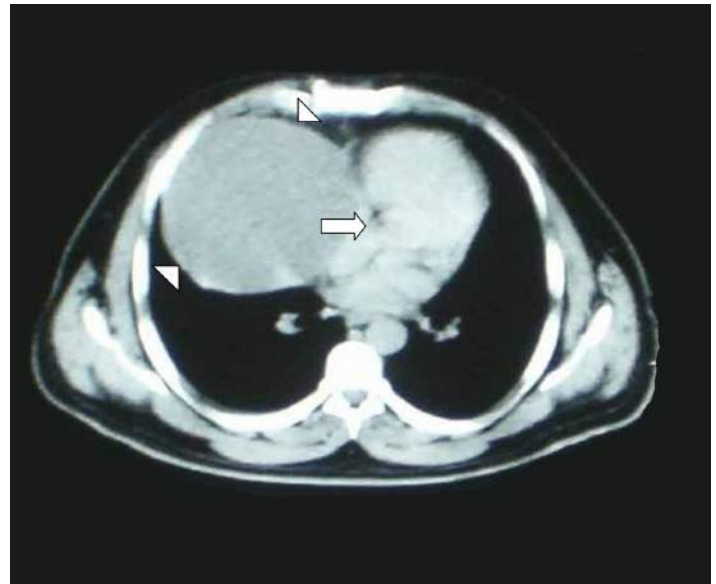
Contrast-enhanced computed tomography showing a large cystic mass (arrowheads) causing cardiac compression (arrows).
